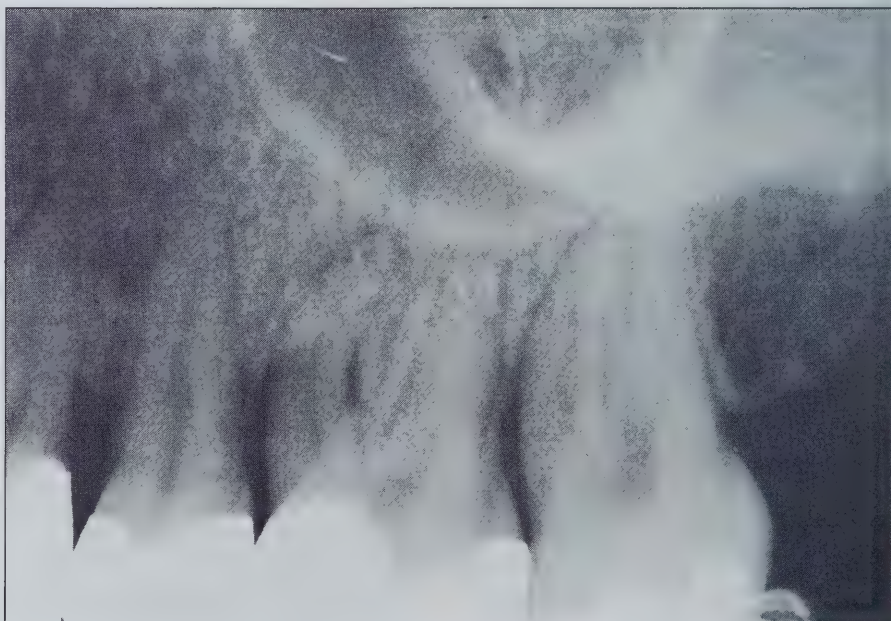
Deep restorations, widened PDL and periodontal bone loss involve several teeth. Radiographs were of little value in isolating the source of pain.
